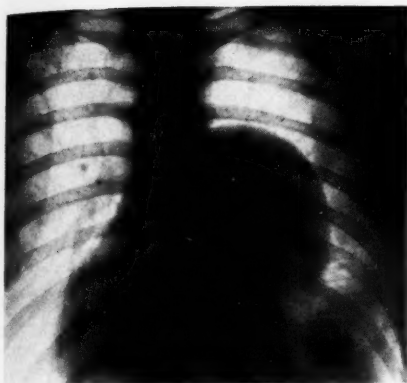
Case 2: Thoracic neurinoma, posterior roentgenogram.
